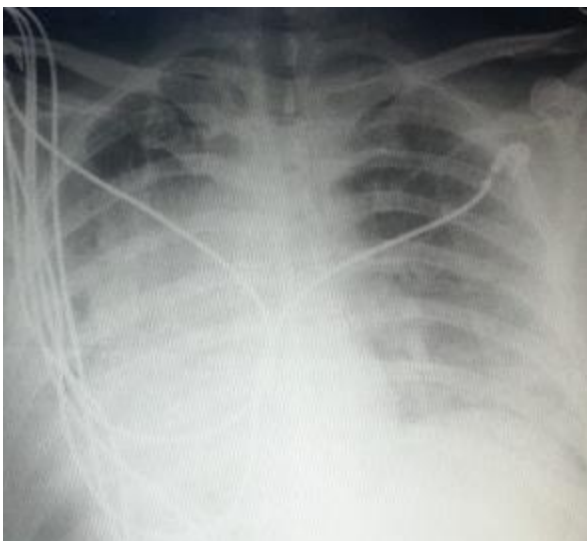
The Chest X-ray on admission
